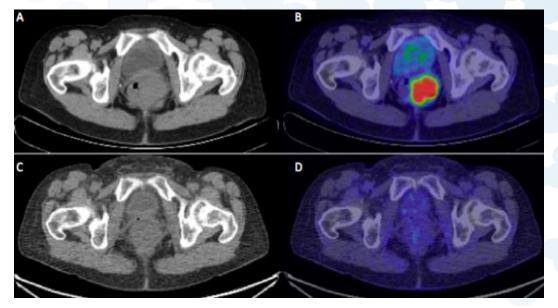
CT (A) and PET-CT (B) of a patient with T2 N0 squamous cell carcinoma of the anus before treatment; CT (C) and PET-CT (D) in complete metabolic response 6 months after radiochemotherapy.
